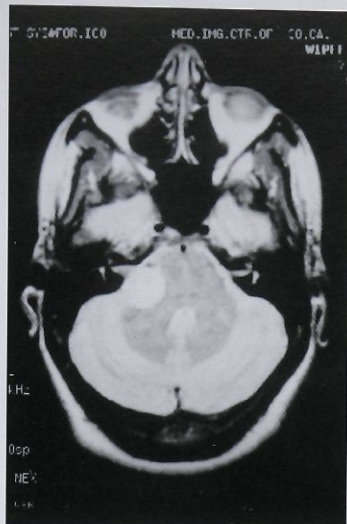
Axial gadolinium-enhanced MRI shows a mass suggestive of an acoustic neuroma or meningioma at the right cerebellopontine angle.
